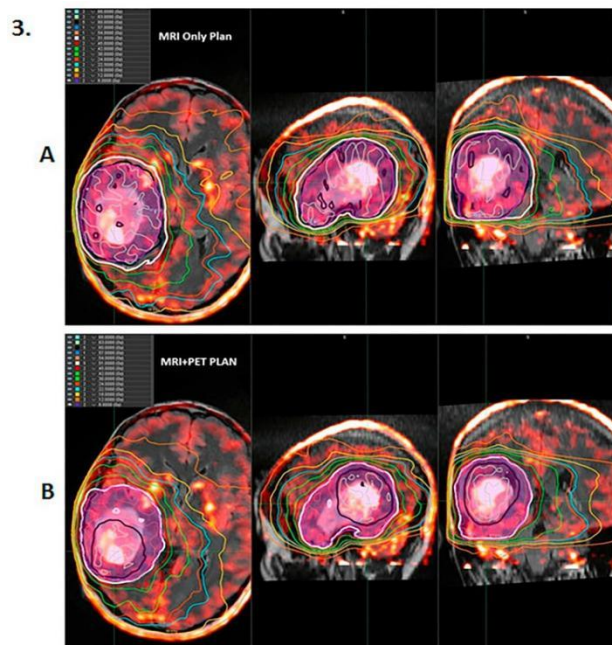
Isodose MRI (A) and MRI + PET (B) schemes. The black equal dose represents the prescribed dose (60 Gy). The magenta segment stands for PTV_{60Gy} . The discordant area was covered with 51 Gy (white equal dose) in the MRI + PET program (B).
